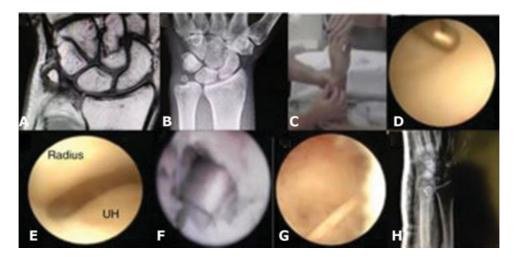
Patient with an Atzei class 3 lesion. (A) Nuclear magnetic resonance imaging shows a lesion at the deep portion of the triangular fibrocartilage complex (TFCC); (B) radiography; (C) clinical assessment of distal radioulnar joint (DRUJ) instability; (D) the superficial portion of TFCC is intact when viewed at the 4-5 portal; (E) DRUJ instability evaluated through the distal dorsal radioulnar portal; (F) anchor placed at the ulnar head through the direct foveal portal; G, fibrocartilage suture viewed through the 4-5 portal; (H), postoperative radiography.
